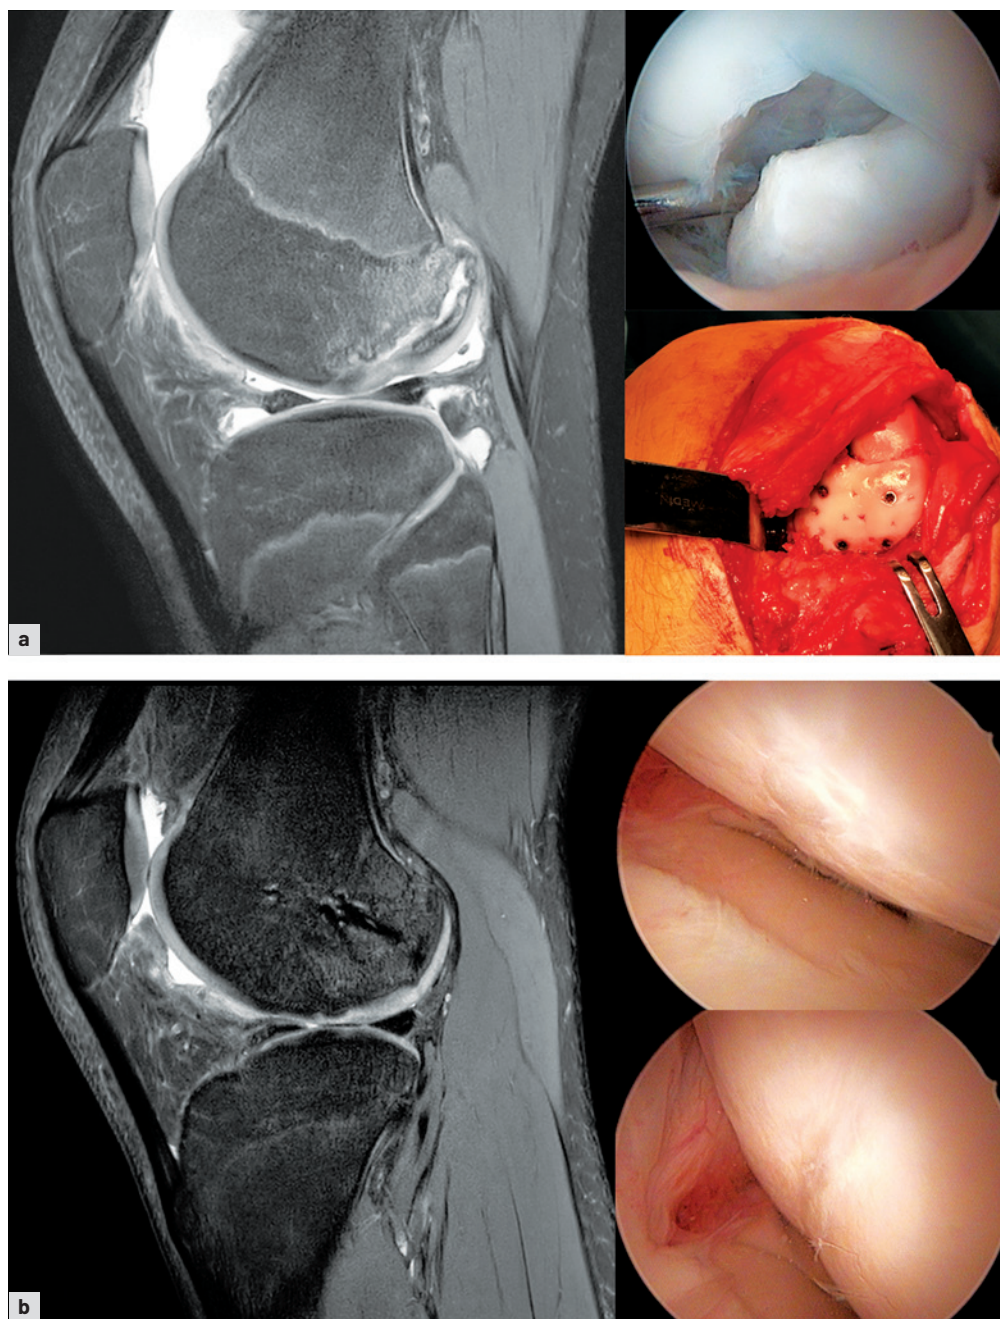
A rare case of massive OCD of the lateral femoral condyle. Preoperative MRI scan, peri-operative arthroscopic findings, and fixation with 4 MAGNEZIX screws (a), MRI and arthroscopic exploration 24 months after surgery show good integration with mild signs of chondropathy (b).
